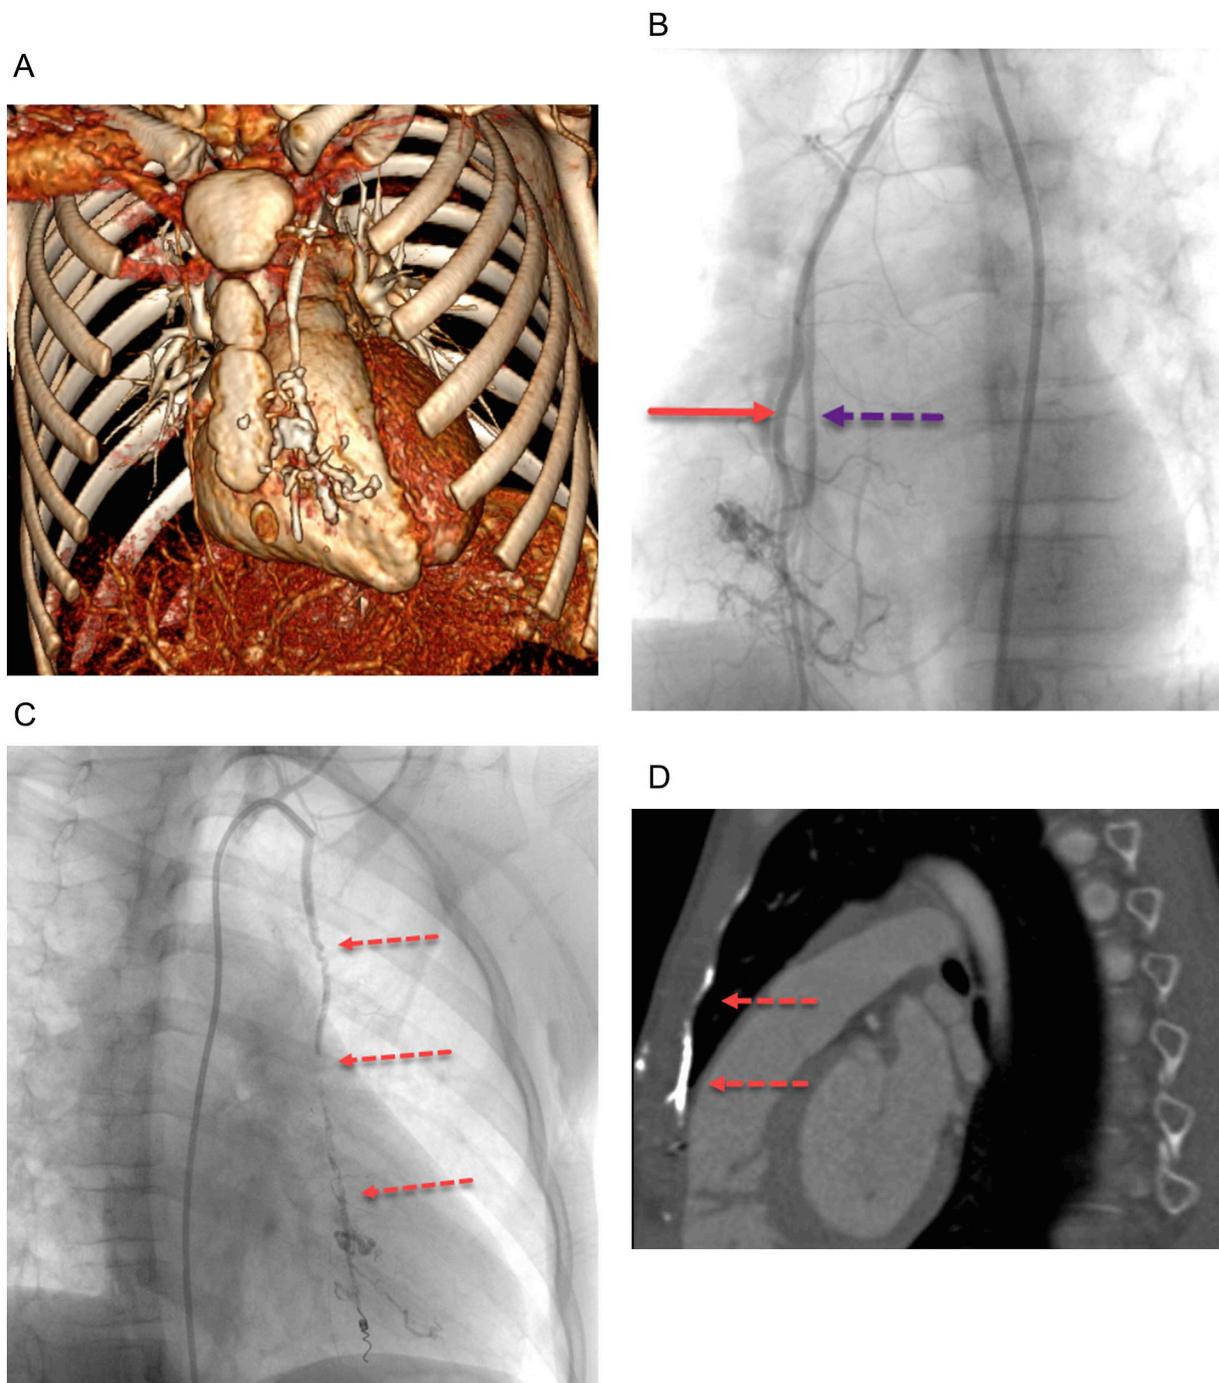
a. Given the patient's constellation of history and physical exam findings, a CT scan was obtained which demonstrated an arteriovenous malformation (AVM) arising off the left internal mammary artery. A 3D rendered image of the CT scan delineates the extent of the AVM.
